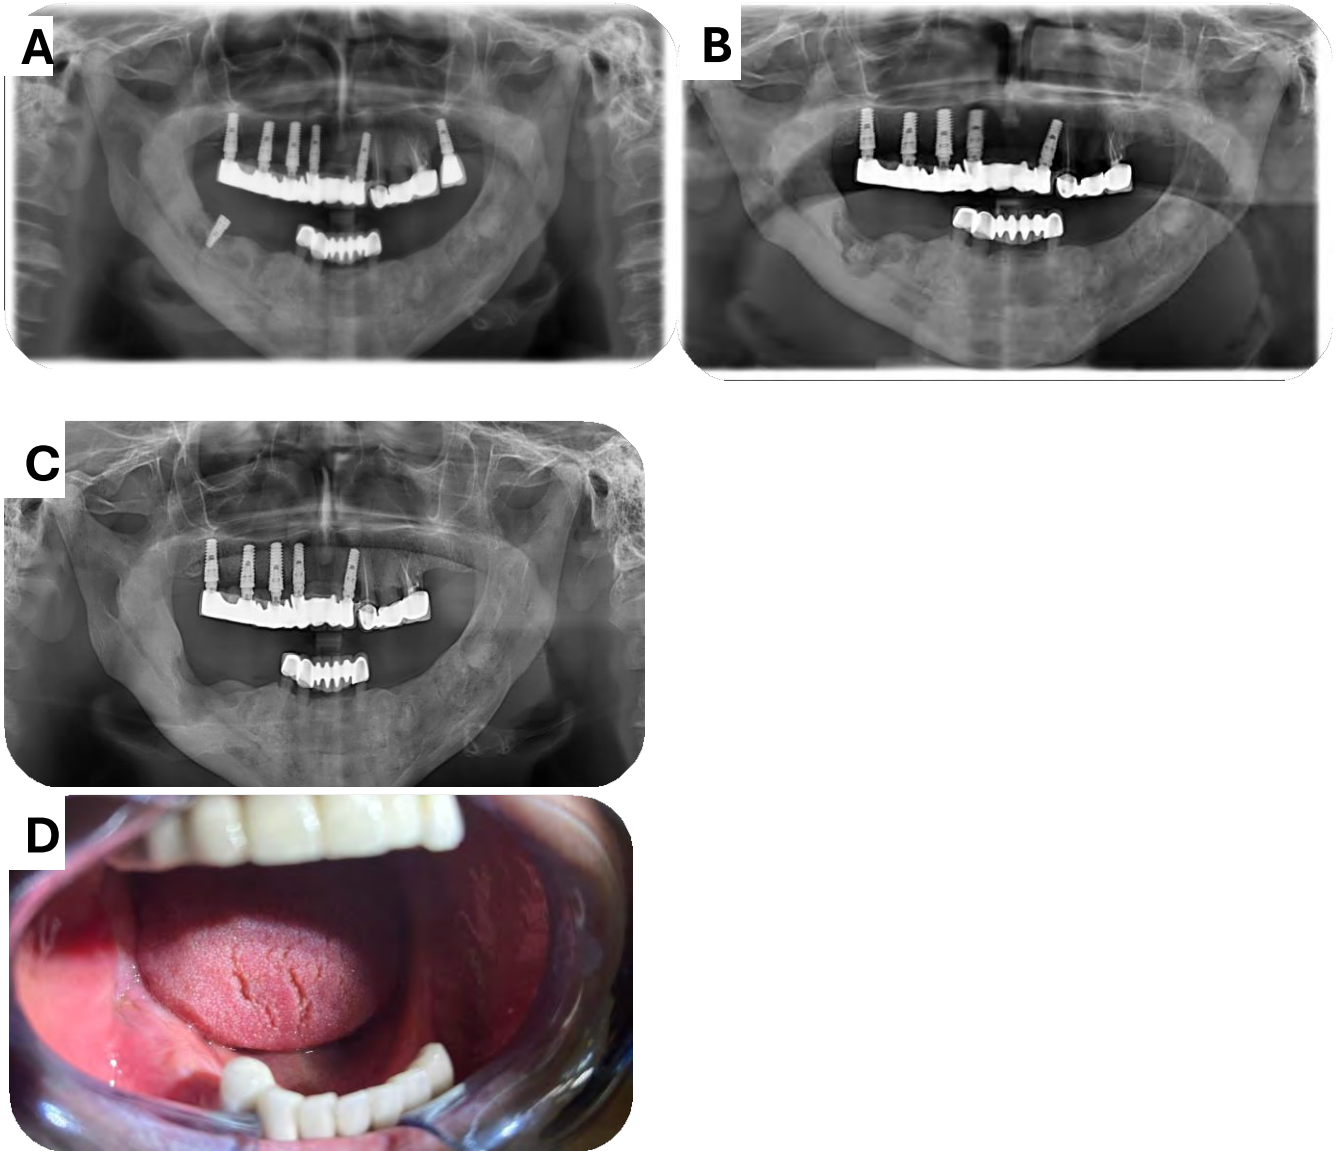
A: Postoperative radiographic view , B: Radiographic view after implant removal, C: 3 months post-surgical radiograph , D: Postoperative 9 months
